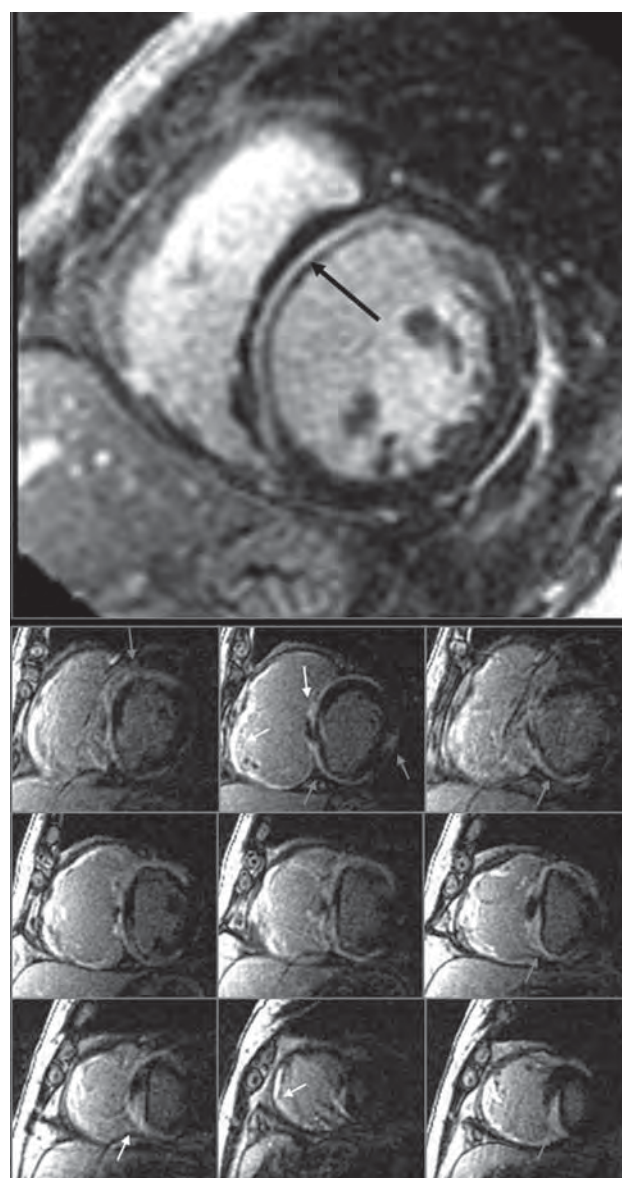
Cardiac magnetic resonance imaging (CMR). Top image: CMR utilizing a myocardial delayed enhancement sequence 10 minutes after administration of intravenous gadolinium. Patients with DCM most commonly have no delayed enhancement, while some may have a mid-myocardial stripe of delayed enhancement in the interventricular septum (black arrow). Bottom image: CMR utilizing a myocardial delayed enhancement sequence 10 minutes after administration of intravenous gadolinium. Short-axis imaging from base (upper left) to apex (lower right) demonstrates patchy areas of delayed enhancement in a non-coronary distribution with a predominantly subepicardial location (white arrows), consistent with myocarditis.
